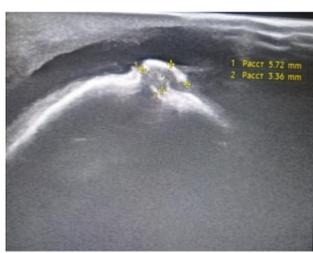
Ultrasound showing fluid-filled cavity with hyperchogenic inclusions and surrounding exostosis
